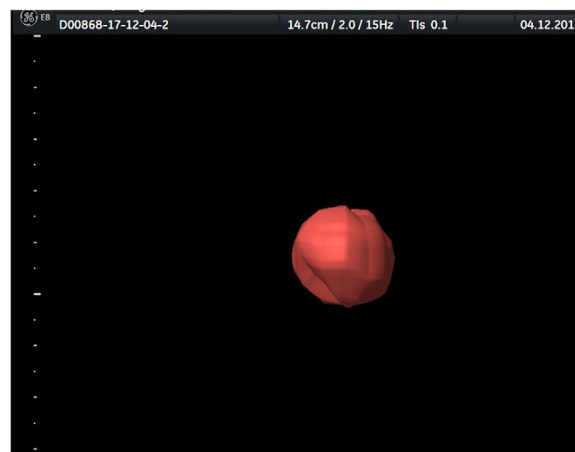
Example of a 3-D ultrasonographic image of the thalamus.
